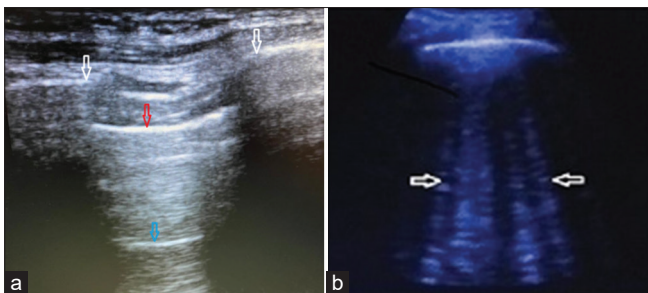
(a) USG lung showing the upper and lower ribs (upper white arrows), the pleural line (red arrow). The A-line (lower green arrow) is the repetition of the pleural line. (b) Showing B-lines or ultrasonic lung comets (white arrows)
